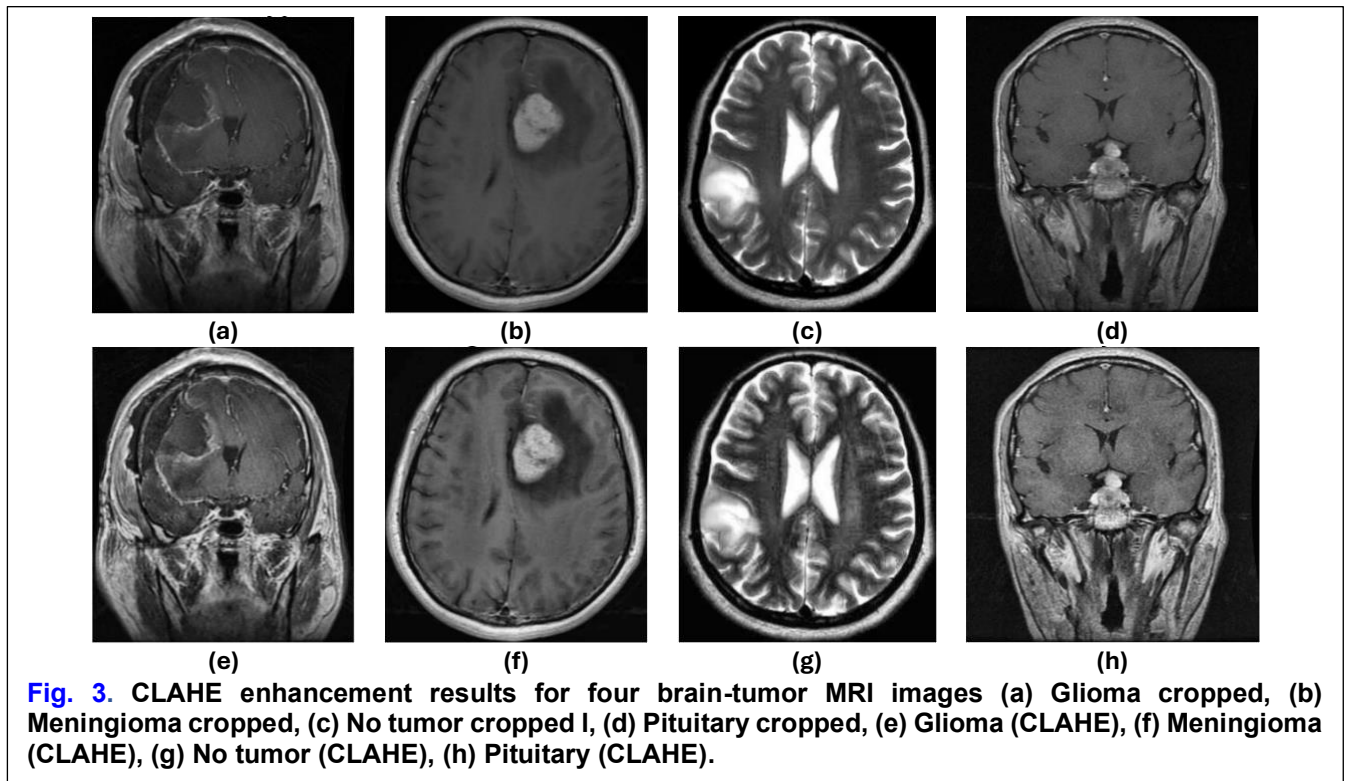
CLAHE enhancement results for four brain-tumor MRI images (a) Glioma cropped, (b) Meningioma cropped, (c) No tumor cropped I, (d) Pituitary cropped, (e) Glioma (CLAHE), (f) Meningioma (CLAHE), (g) No tumor (CLAHE), (h) Pituitary (CLAHE).
